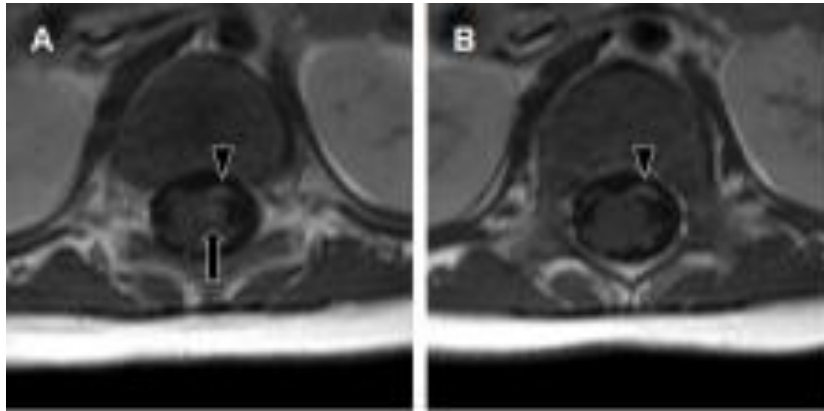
Spine magnetic resonance imaging findings in a 4-month-old infant. The patient presented with acute motor weakness of the left lower extremity along with enterovirus 71 infection. (A, B) Note the strong enhancement of the left anterior horn of the spinal cord (arrow) and the left ventral nerve roots (arrowhead) on gadolinium-enhanced T1-weighted images.
